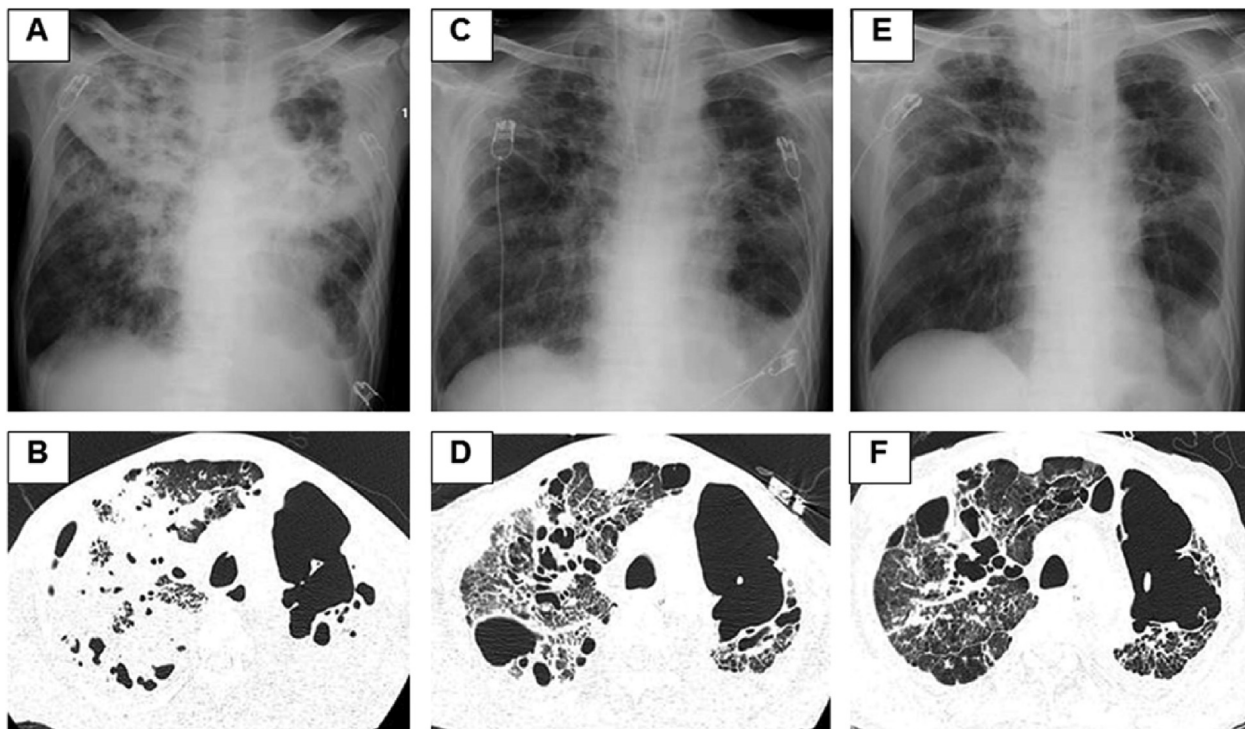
Chest X-ray and computed tomography images. (A) and (B): On the day of admission to our hospital. (C) and (D): 3 days after the discontinuation of extracorporeal membrane oxygenation. (E) and (F): 2 weeks after weaning from mechanical ventilation.
